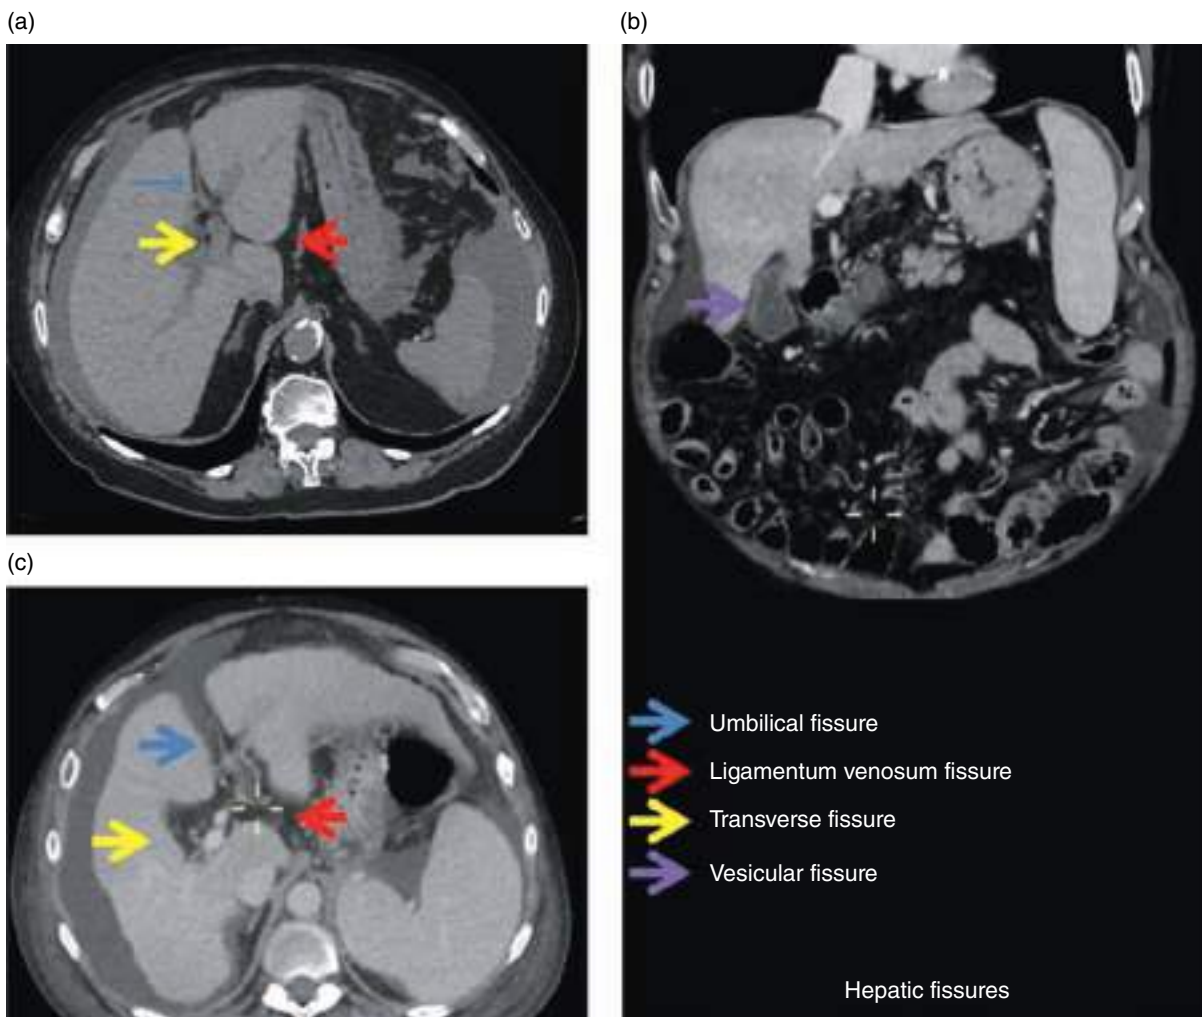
Fissures of the liver in a patient with cirrhosis and moderate free ascites. (a) Axial noncontrast CT image. (b) Coronal contrast-enhanced MPR CT image (portal venous phase). (c) Axial contrast-enhanced CT image (portal venous phase).
